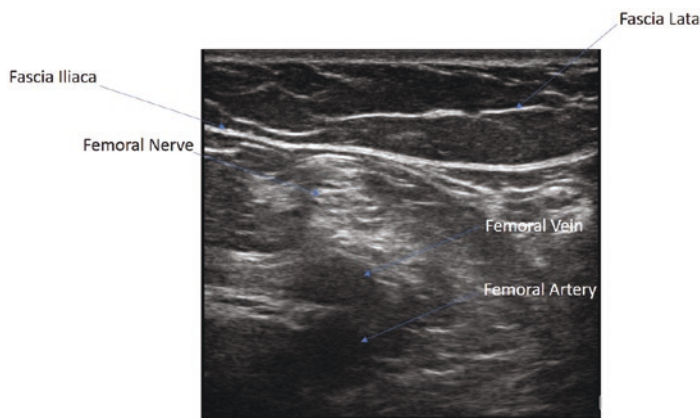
Ultrasound view of the femoral nerve block
